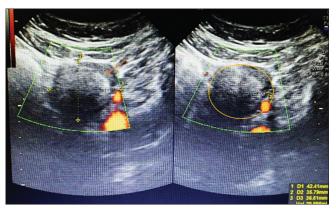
Transvaginal ultrasound showing the left ovary (arrow) measuring $42.4 \times 35.1 \times 36.6$ mm (Volume = 29.0 cc) with few small follicles and a well-circumscribed, hypoechoic solid mass that has no color flow (B5) measuring $36.8 \times 34.0 \times 32.1$ mm (Volume = 21.0 cc)
